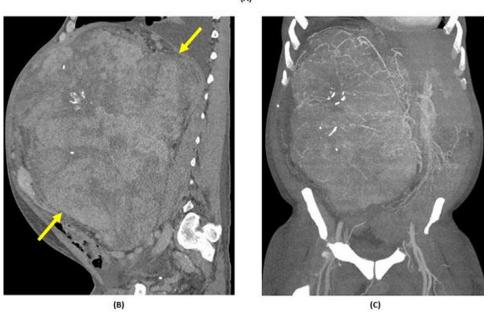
A 58-year-old male presented to his local emergency department for new onset scrotal swelling in addition to worsening abdominal and lower extremity swelling over the past year. A computed tomography (CT) scan was performed for further evaluation. (A) Axial CT demonstrates a large retroperitoneal mass measuring 28 x 22 x 33 cm with an irregularly lobulated contour (arrows). Faint calcifications can be seen within the mass. (B) Redemonstration of mass on sagittal CT (arrows). Note faint calcifications and irregular enhancement. (C) MIP imaging in coronal plane defines extensive vascularity of the tumor and its lack of defined margins.
